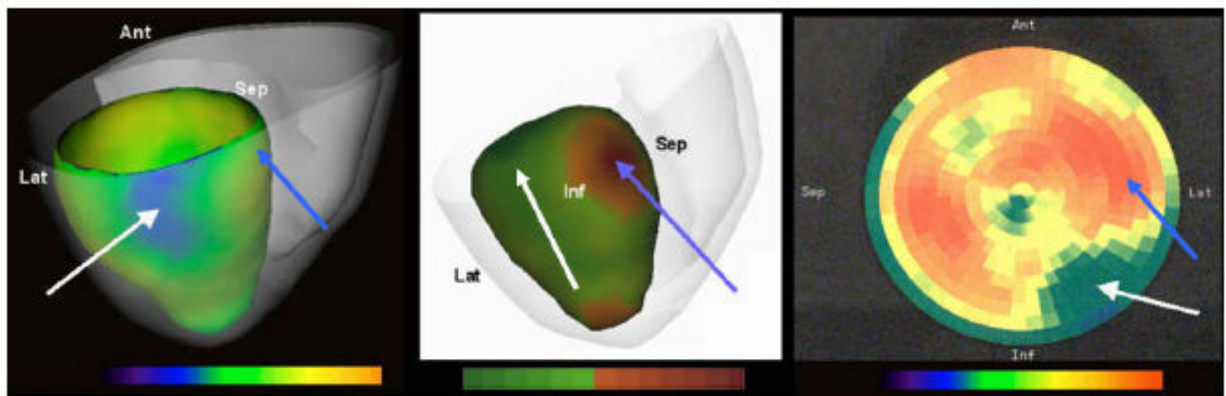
Représentations en 3-D de la captation du FDG (gauche) et des valeurs de densité de courant (milieu) sur un modèle de cœur biventriculaire du patient E1. Pour la comparaison des modes de présentation de l'information, la représentation polaire 2D réalisée manuellement (logiciel Siemens ; Turku PET center) de l'image TEP-FDG correspondante est représentée à droite. Une zone nécrosée postéro-latérobasale est identifiée ; elle est colorée en bleu au niveau de la base sur la représentation en 3-D (à gauche, flèche blanche) et en vert foncé dans l'image polaire (à droite, flèche blanche). Dans les données MCG (milieu), les amplitudes de courant les plus faibles sont aussi représentées en vert foncé (flèche blanche) et les amplitudes les plus élevées peuvent être observées en rouge au niveau basal (flèche bleue).
